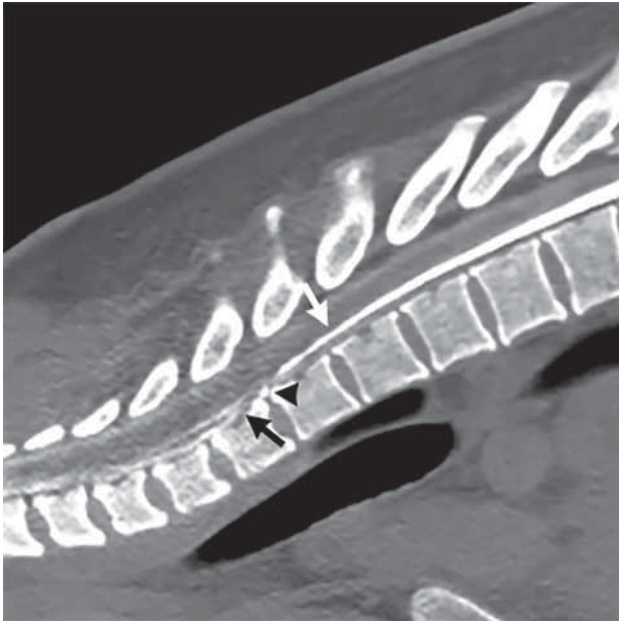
Type 1 CSF leak (dural tear): dynamic CT prone myelogram in the sagittal plane shows normal myelographic contrast in the subarachnoid space (white arrow) until there is a transition point at the T1–T2 level where there is a calcified disc (black arrowhead) that results in a split of contrast between the subarachnoid and ventral extradural spaces (black arrow).
